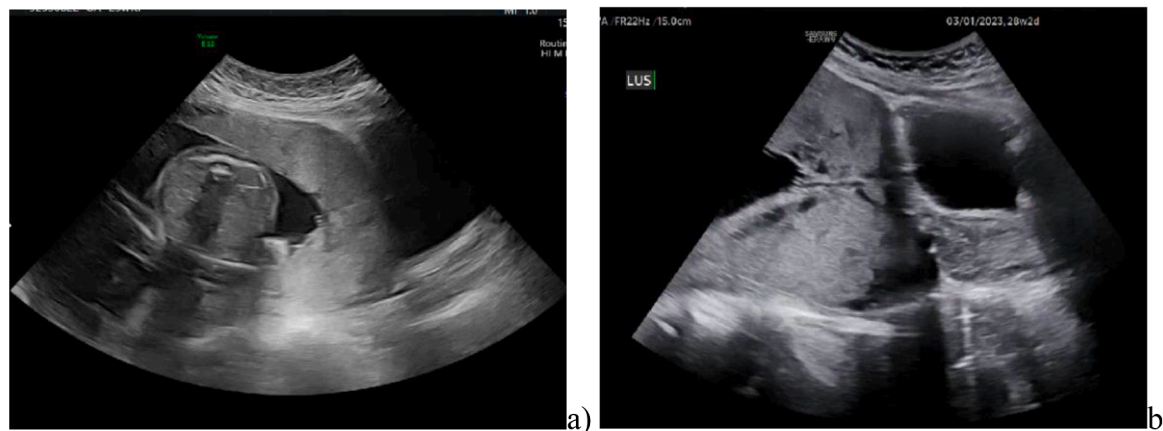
Transvaginal sonographic images. A). A central placenta previa was seen at 23 weeks' gestational age. The placental-vesical interface is obliterated. There is loss of the normal hypoechoic plane in the posterior myometrium beneath the placental bed. B). Repeat transvaginal ultrasound at 28 weeks' gestational age. There is bulging of the posterior placenta into surrounding region. Multiple placental lacunae seen.
